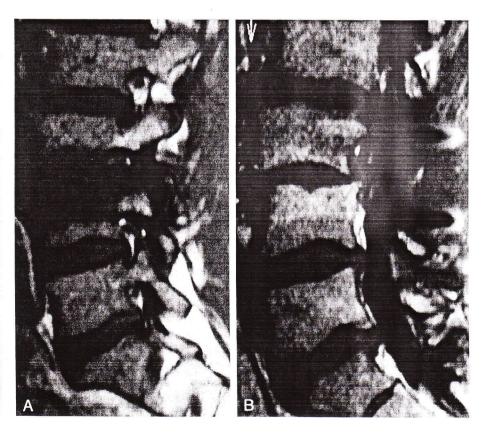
Change from Modic Type 1 signal (A) to Modic Type 2 signal (B) after arthrodesis in a patient with L3–L4 spondylolisthesis caused by isthmic lysis (T1-weighted sequences).
